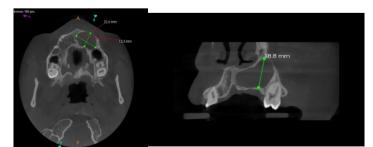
Figure Showing Cbct Images Of The Same Lesion In Axial (I) And Sagittal Section (Ii)
